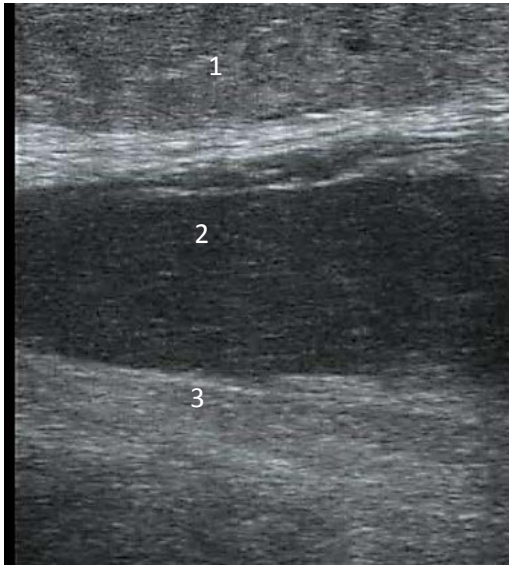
Ultrasound. B-mode.
